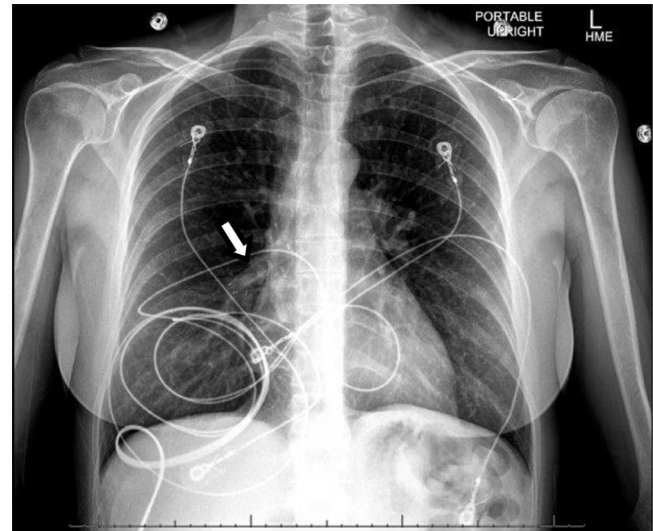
(A) – Portable upright AP radiograph demonstrating a retained stent in a proximal right pulmonary artery (white arrow). (B) Subsequent CT of the chest was performed demonstrating the stent in the proximal right middle pulmonary artery on maximum intensity projection imaging (white arrow).
